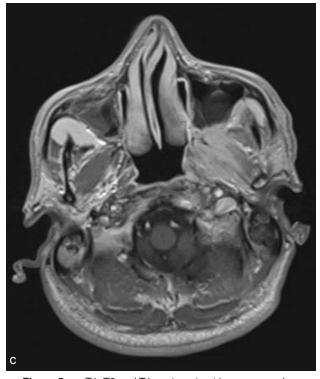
T1, T2 and T1 post-contrast images reveal an abnormal signal intensity lesion in left nasopharyngeal soft tissues with extension into left maxillary sinus projecting into the nasopharyngeal air way. It appears iso-intense on T1 and hyper intense on T2-weighted images showing post-contrast enhancement.
